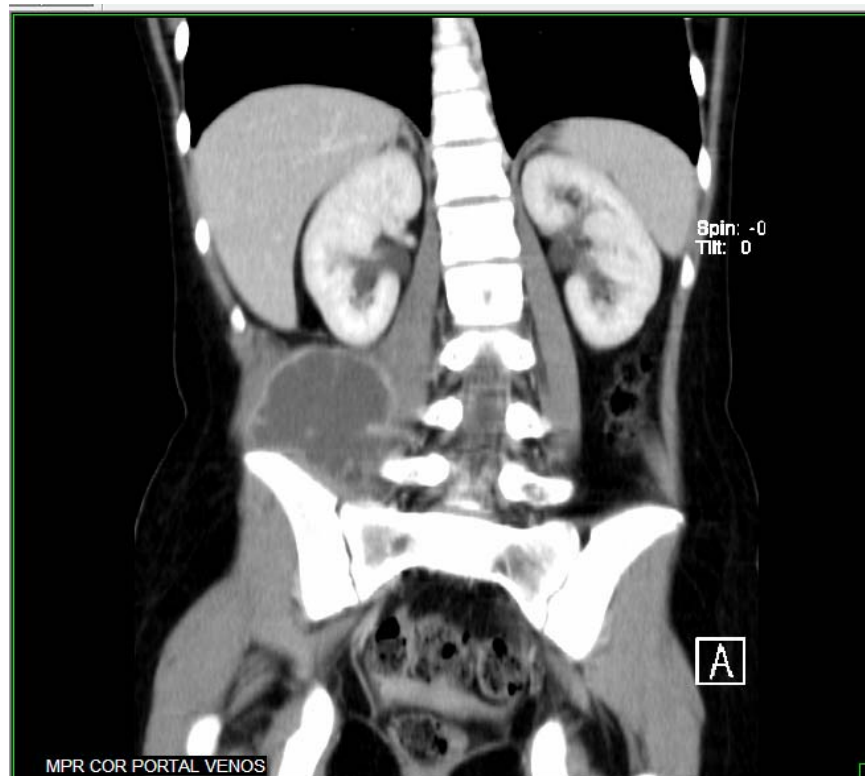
CT scan with contrast, coronal view, showing a gross loculated retroperitoneal collection in the right lower quadrant. The mass comes in contact with the iliopsoas muscle and extends cephalad to the inferior pole of the kidney.*
